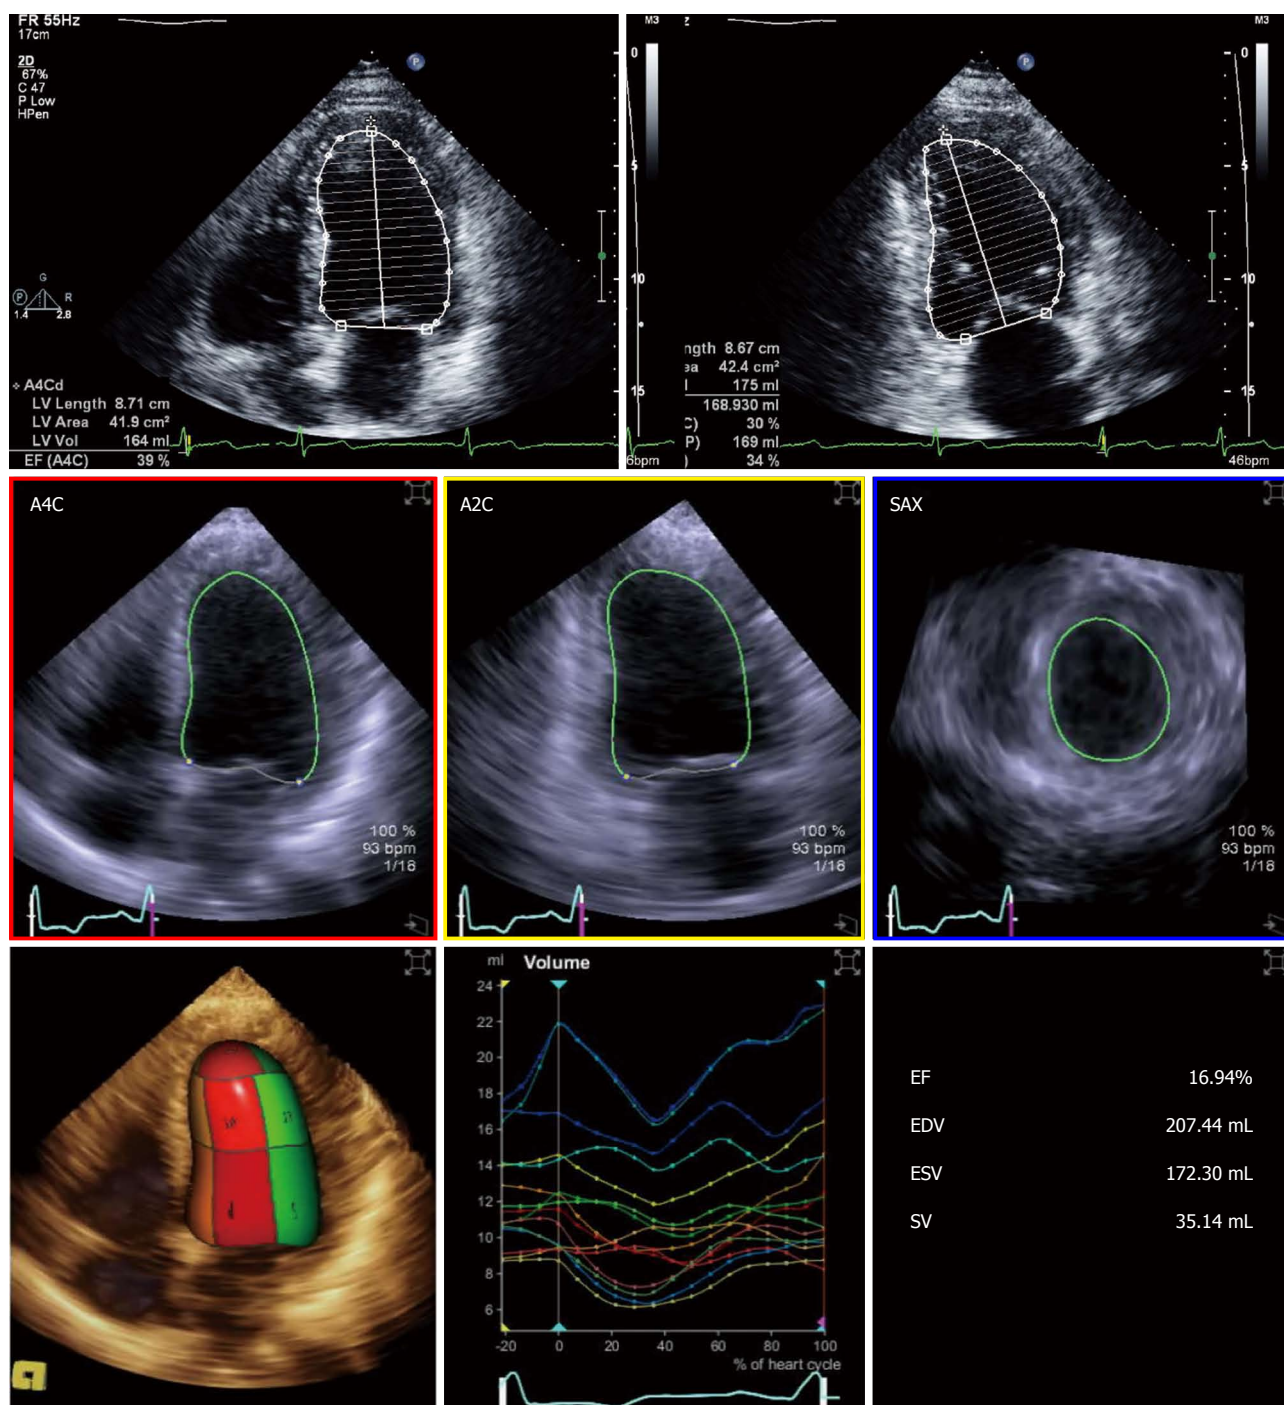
Ejection fraction determination using two-dimensional (biplane Simpson's method - upper panel) and three-dimensional echocardiography (fully automated software - lower panel).
